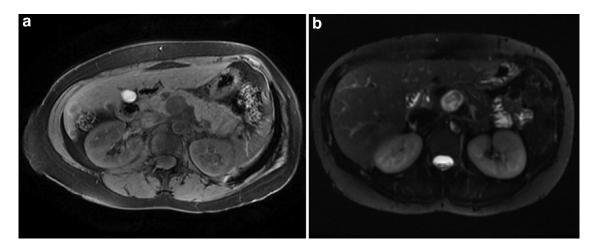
Axial T1 (left) and T2 fat-saturated (right) MRI images demonstrate a well-circumscribed 2.5 x 2.0 cm mass in the neck of the pancreas with low T1 and heterogeneously increased T2 signal intensity.
